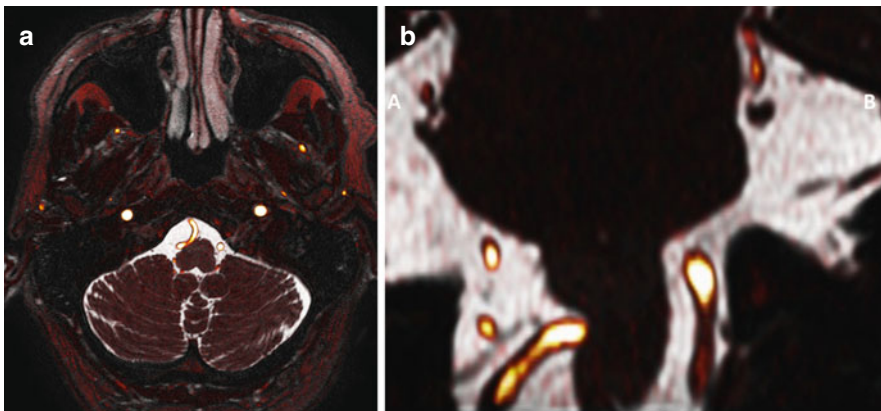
MRI with fusion of T2 and TOF-angio in a patient with apparent essential hypertension. Axial (a) and coronal (b) views of the vertebral artery compressing the ventrolateral aspect of the medulla on the right side
